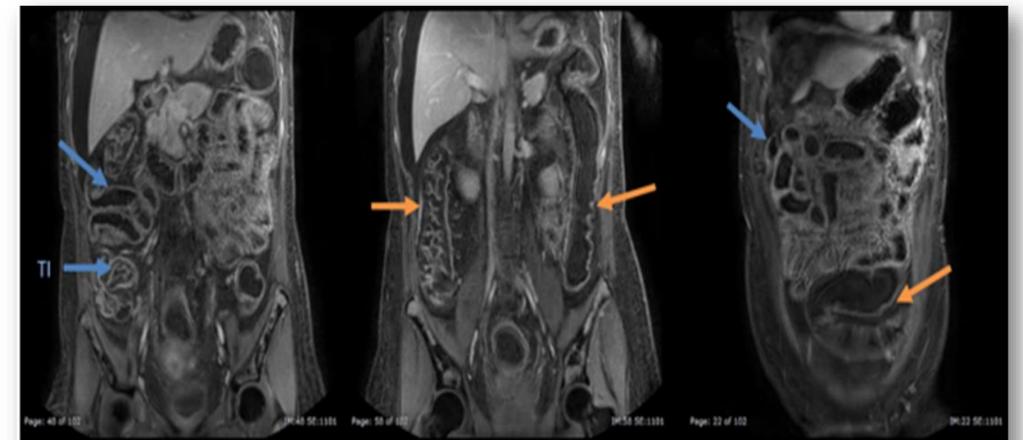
Magnetic Resonance imaging Enterography
